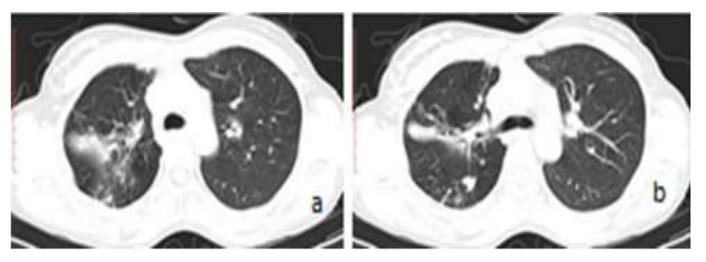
HRCT Chest.a) upper part of the right middle lobe with evidence of inhomogenous opacity with decrease in lung volume.b) axial section just below the bifurcation of trachea showing plate like atelectasis.
